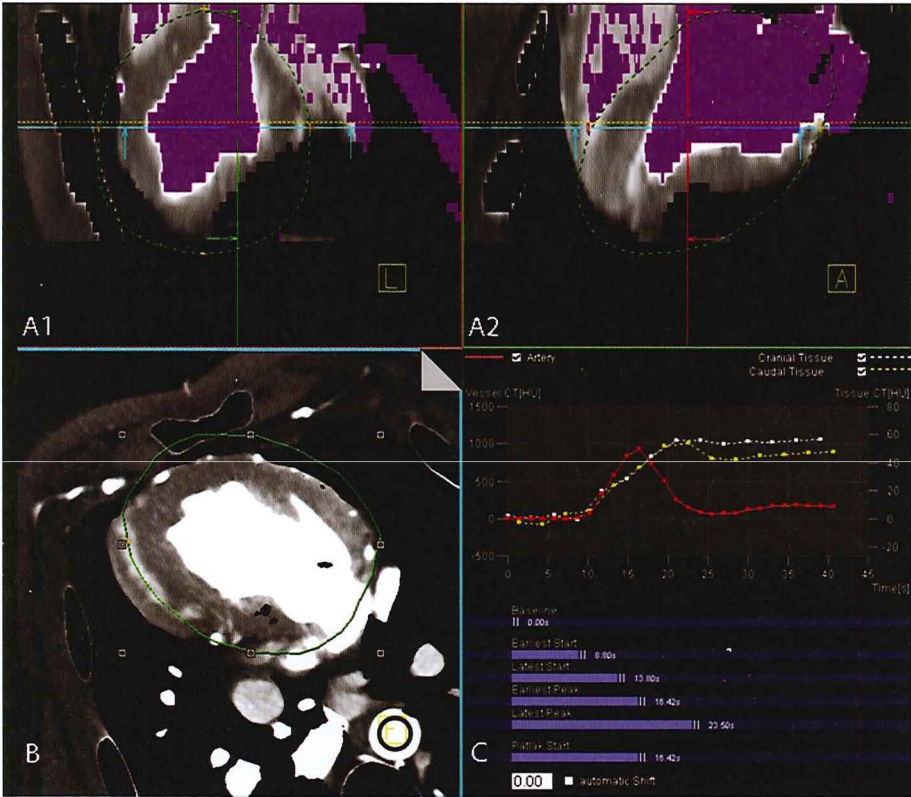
CT-perfusion imaging post-processing. Screenshot of the post-processing software. Panels A1 and A2 show the segmentation of the left ventricle. The left ventricle myocardium is isolated using in combination a Hounsfield unit based thresholding and a peak enhancement analysis within a volume of interest, VOI (green line). The arterial input function is sampled from two regions of interest placed in the descending aorta of the cranial (panel B) and caudal part of the image stack. One arterial input function is then obtained (red time-attenuation curve, TAC) in panel C combining the information of both ROIs.
